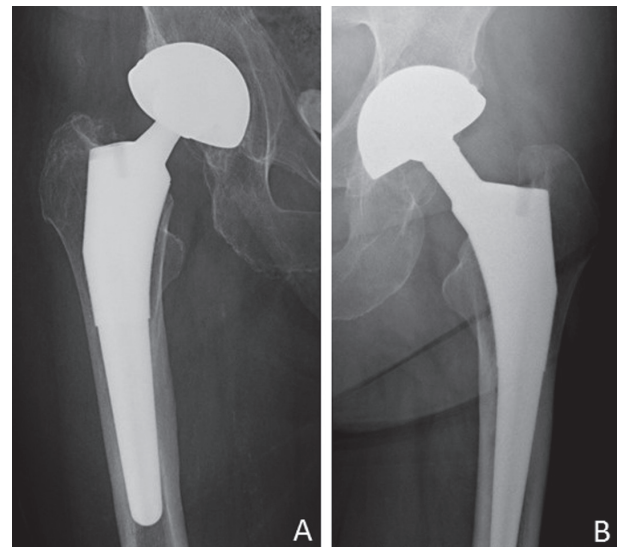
Five years follow-up radiographs of two different cases showing partial (A) and complete (B) cup integration according to Moore criteria. No sign of loosening is present
